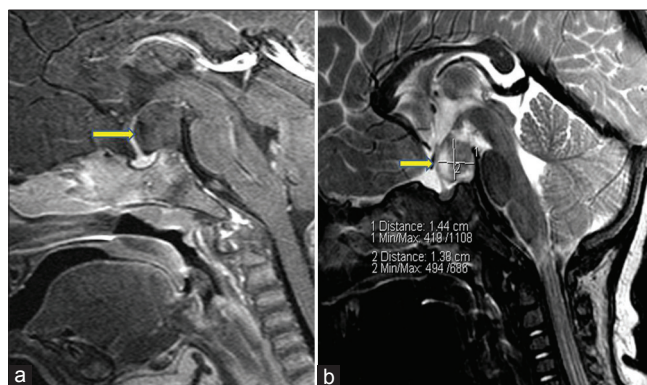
(a) Plain MRI Brain (T1W image) revealing sessile, well-defined hypothalamic mass is intense to gray matter (b) MRI brain, post contrast, revealing a hyper intense mass lesion suggestive of hypothalamic hamartoma, measuring 1.44 × 1.38 cm
